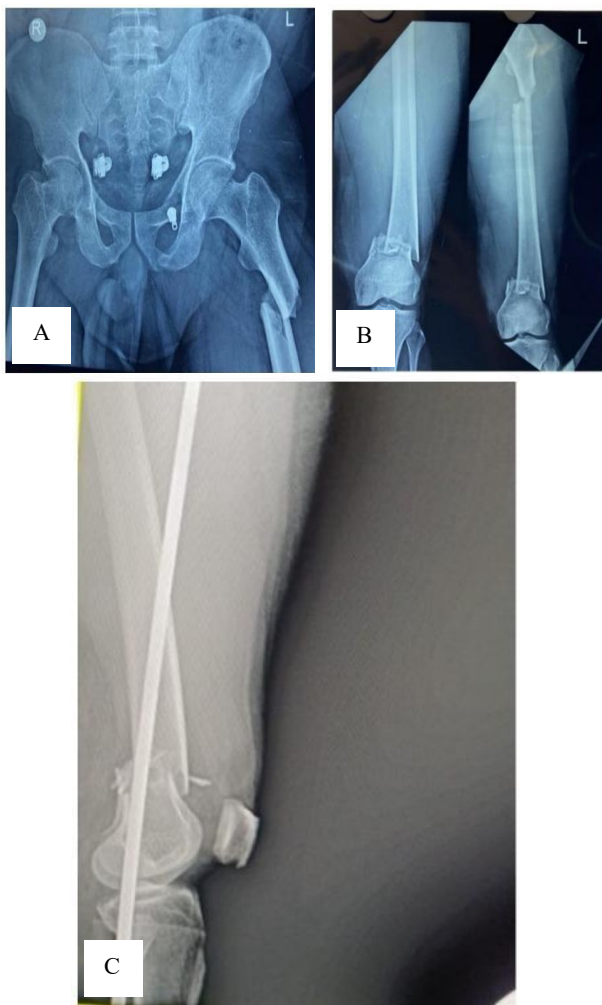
Pre op X-rays: (A) X-ray pelvis with both hips-AP view, (B) X-ray left femur-AP view and (C) X-ray left femur-lateral view.
